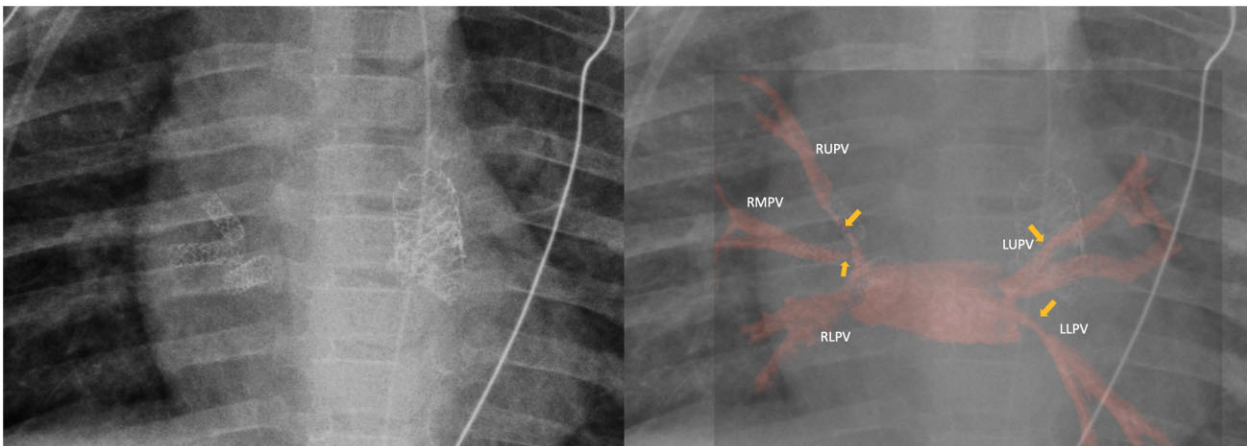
Fluoroscopic demonstration of stents: the fluoroscopic image on the left demonstrates the five pulmonary vein stents. Note the stents in all of the pulmonary veins, as well as the larger stent in the right ventricular outflow tract. The second image on the right demonstrates the stents superimposed on the computed tomography reconstruction of the pulmonary veins.
